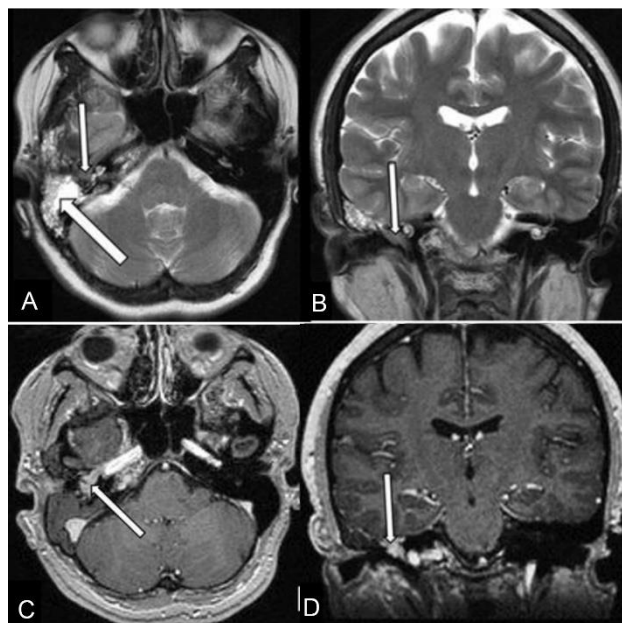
MRI of temporal bones, T2 images (A, B): A soft tissue formation in the right tympanum exhibiting a low signal (narrow arrow) and liquid content in the antrum and pneumatic cells of the right mastoid process exhibiting a high signal (wide arrow). In T1 contrast enhanced images (C, D), a formation in the right tympanum can be seen, intensively imbued with contrast (narrow arrow). The liquid content in the antrum and pneumatized mastoid cells does not show imbibition.
